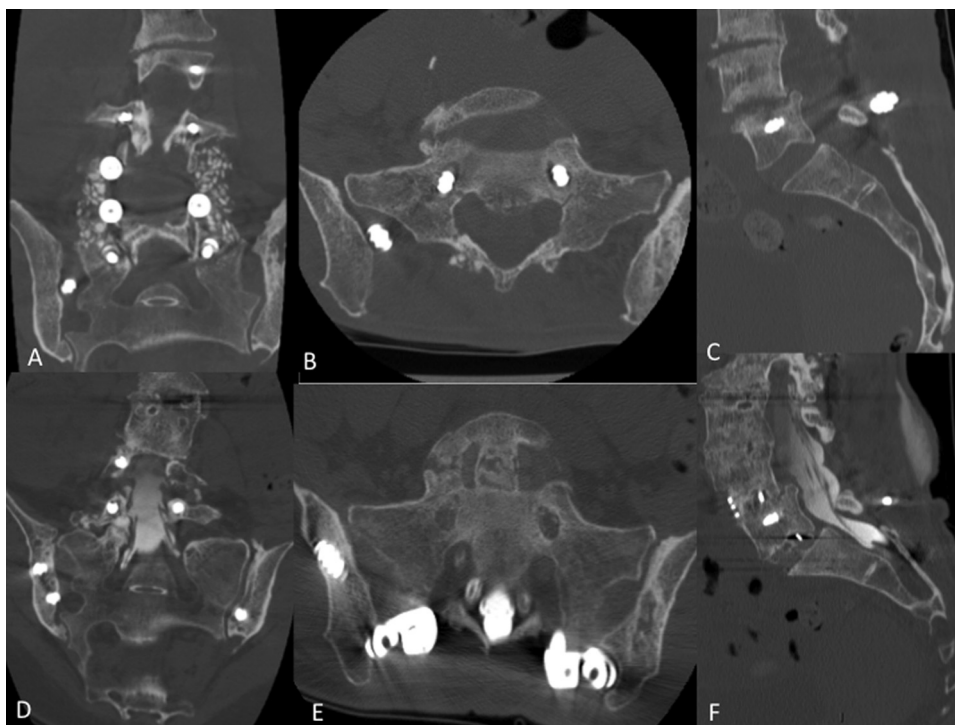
CT-scans before (A, B, C) and one year after revision surgery for sacral stress fracture of case 3 (D, E, F). Diagnosis stayed difficult even with the use of CT-scan. At one year after surgery, consolidation was done with a circumferential L5-S1 fusion. Despite peroperative X-ray control of screws positioning, iliac screws were sometime more in the sacro-iliac articulation than in only in iliac bone (A, B, C).
